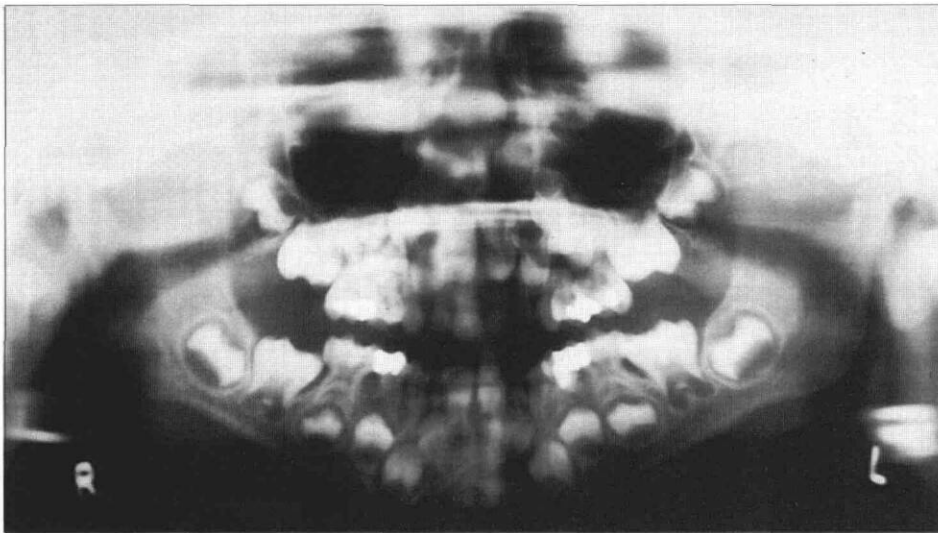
Panoramic radiograph at age 7 showing the presence of taurodontia in the mandibular primary second molars.
